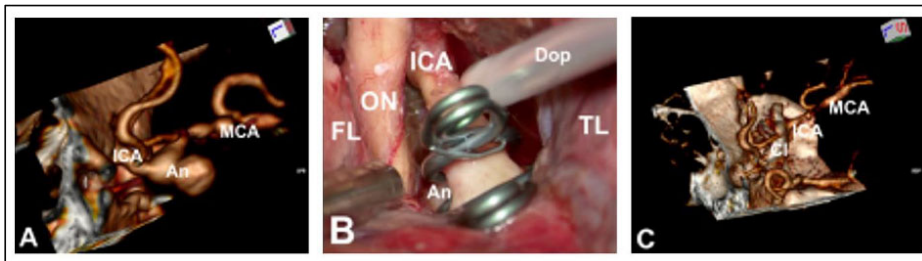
A: Pre-operative CTA showed a giant ICA aneurysm pointed in superoposterior direction. B: The tandem clipping technique (Drake's technique) occludes the aneurysm while preserving the ICA. In this case, we did not have clips with an appropriate ring and blade size. However, the surgery was done well, and the patient achieved an excellent clinical outcome. C: Postoperative CTA showed that the aneurysm is occluded and ICA, MCA, and ACA are well preserved.
